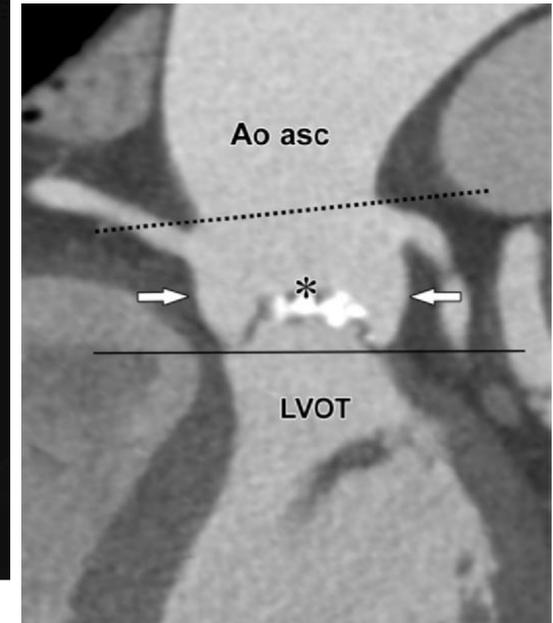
Coronal contrast-enhanced CT image shows the aortic root extending between the LVOT and the ascending aorta (*Ao asc*), with its borders formed by the sinotubular junction (dashed line) and the basal attachments of the aortic valve leaflets, which define the level of the annular plane (solid line). The aortic root contains the sinus of Valsalva (arrows) and aortic valve leaflets (*).
